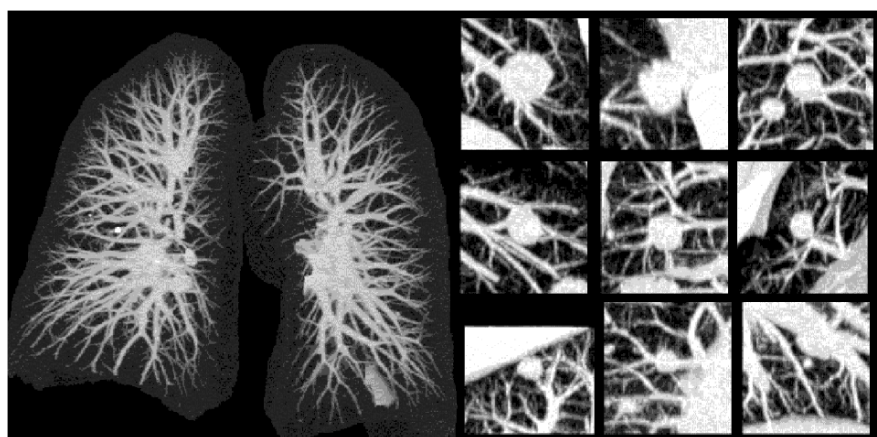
Left: Maximum intensity projection (MIP) of the lung segmented out of a high-resolution CT data set. Right: Examples of nodules of varying size (2–20 mm diameter), hidden in the maze of vessels.
